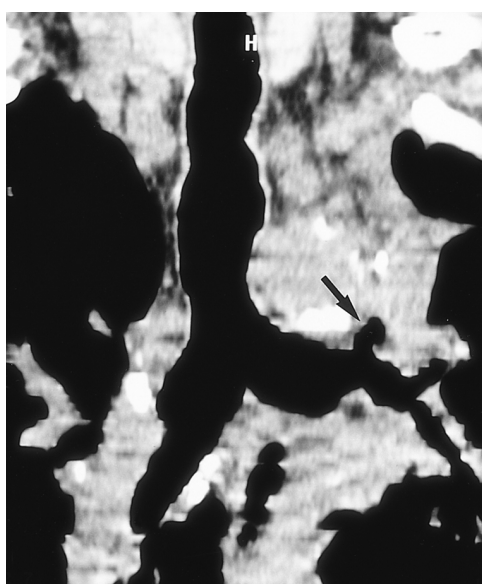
An outpouching lesion at the anastomotic site after sleeve left upper lobectomy in a 67-year-old man. SSD (A), routine enhanced CT (B), and coronal MPR image (C) show an outpouching lesion at the anastomotic site (arrow). For these three techniques, the respective score for relationship was 0, 4, and 3, respectively.
